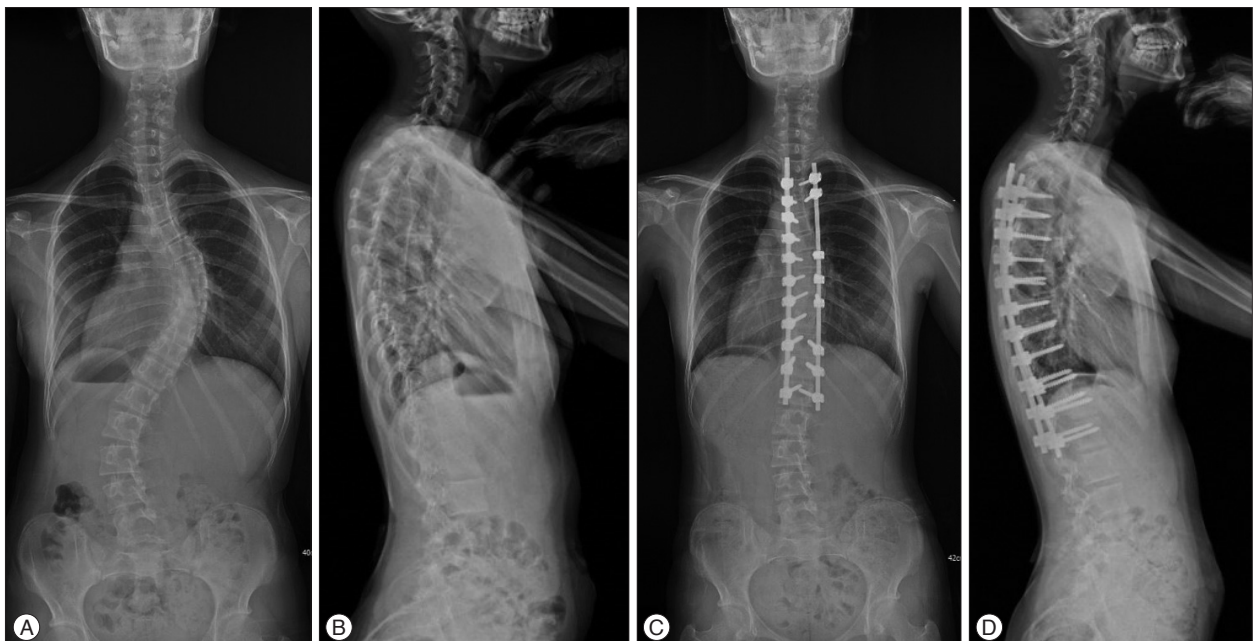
A and B : Preoperative whole spine plain radiograph showing scoliotic curvature with 60 degree Lenke 1BN type. C and D : Postoperative 6 months whole spine plain radiograph demonstrating a balanced spine after surgical correction.
